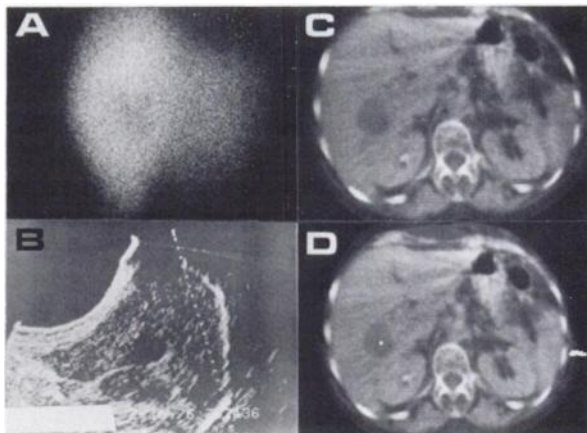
(A, B) Anterior gamma image and longitudinal sonogram: solitary large lesion on ^{99m}Tc study is sonolucent. (C, D) CT images without and with cursor: lesion is identified (C) and its attenuation coefficient determined (D). Blood, pus, and solid or necrotic tumor are excluded by determination of extremely low attenuation coefficient (Delta number = 4). Again, simple hepatic cyst was diagnosed, obviating need for invasive diagnostic procedures.
